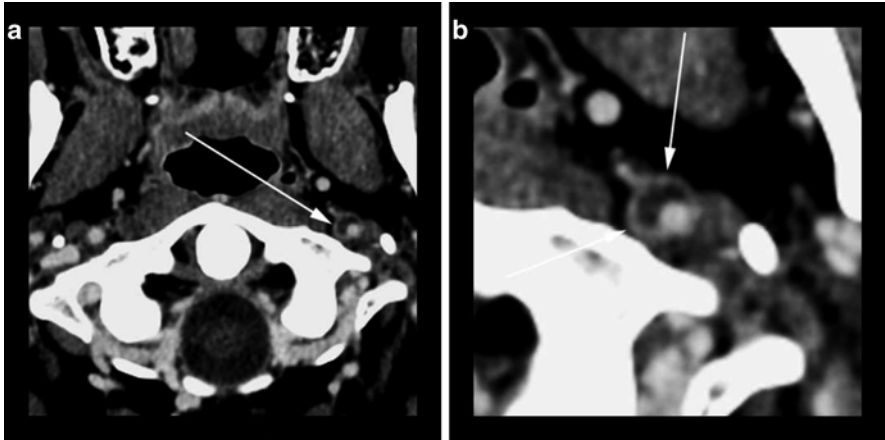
49-year-old male presenting with stroke-like symptoms. (a) Axial CTA image reveals peripheral low density crescentic atherosclerotic plaque and vasa vasorum enhancement (*arrow*). (b) A magnified version of the same image better displays the enhancement of the vasa vasorum (*arrows*)
